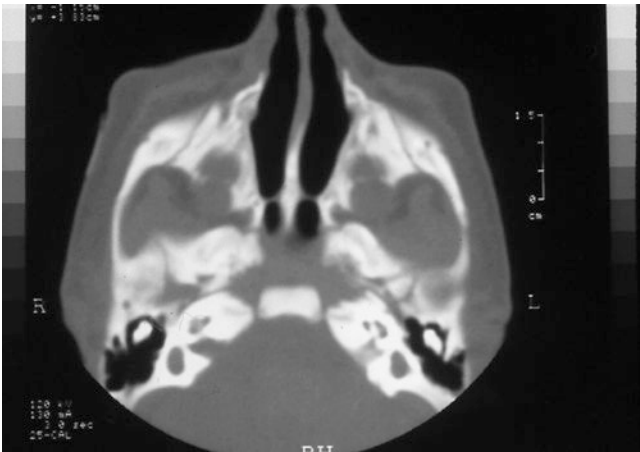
Bilateral membranous choanal atresia. This historical axial CT image shows a thin membrane across the posterior nasal passage bilaterally
